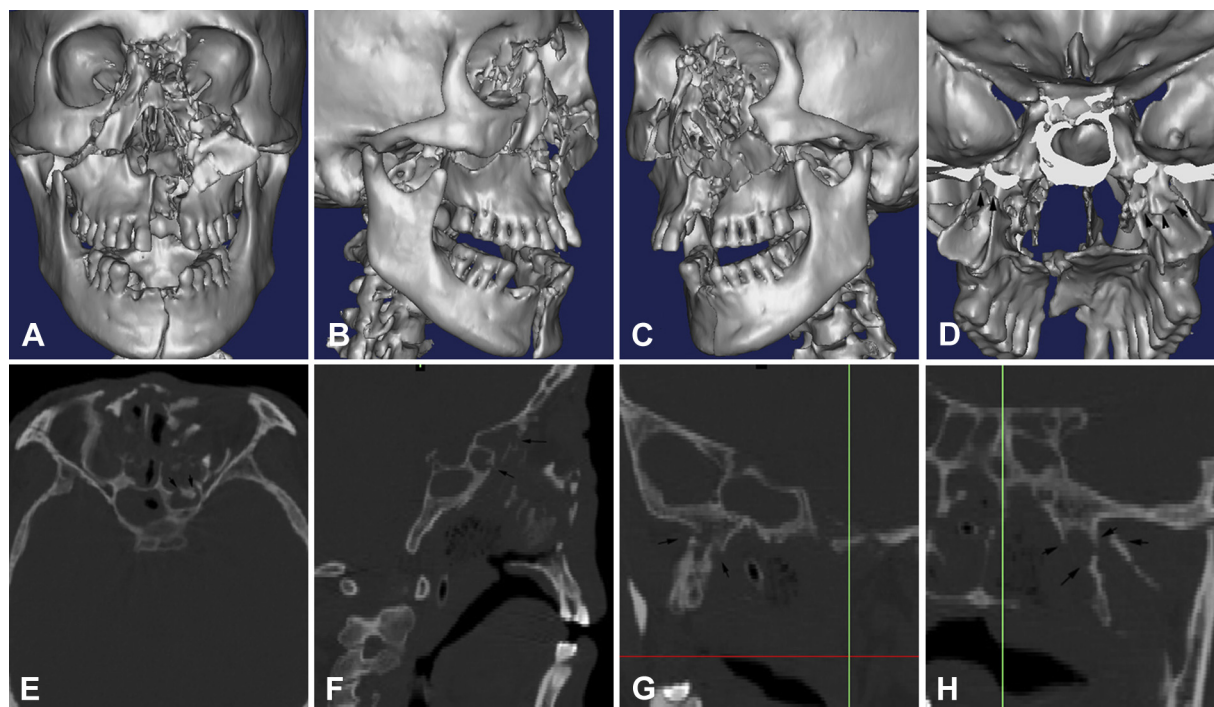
A patient with LeFort I and II maxillary fractures, maxillary sagittal fracture, and nasal-orbital ethmoid fracture. On axial and sagittal computed tomography images, the fractures are seen extending to the ethmoid and sphenoid sinus, from the anterior backward. Neither pterygoid process fracture (right II-1, left II-2) extended to the floor of the sphenoid sinus. Sphenoid sinus fractures of this type are caused by a frontal striking force.
